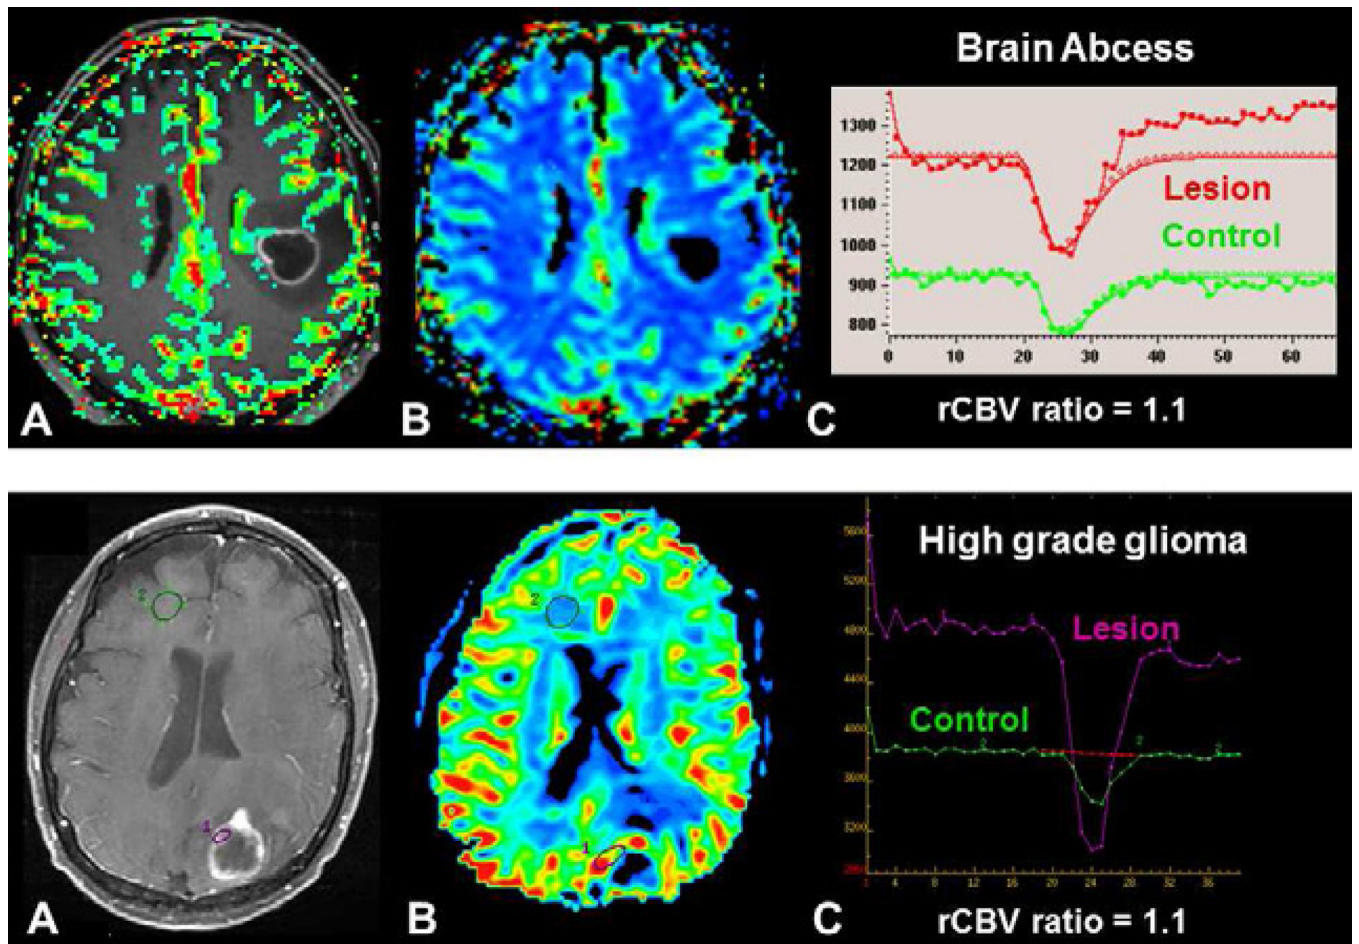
Differential diagnostic of brain tumor using DSC-MRI. Both patients presented with a mass demonstrating central necrosis and peripheral enhancement (A, D). In a brain abscess, (upper row) DSC-MRI demonstrates a low rCBV ratio (C) without visible increased perfusion on the rCBV color map (B), whereas in a brain tumor, in this case a metastasis, (lower row), DSC-MRI demonstrates an increase perfusion within enhanced parts of the lesion (E) with a high rCBV ratio (F).
